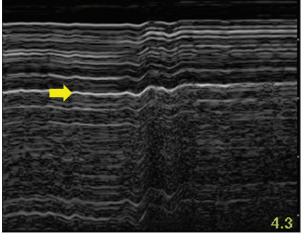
Point-of-care ultrasound showing the bar-code sign. No motion of the chest wall results in a homogeneous, stratified pattern above the pleural line while no motion of the lung because of effective lung separation results in a similar stratified pattern below the pleural line (yellow arrow head)
